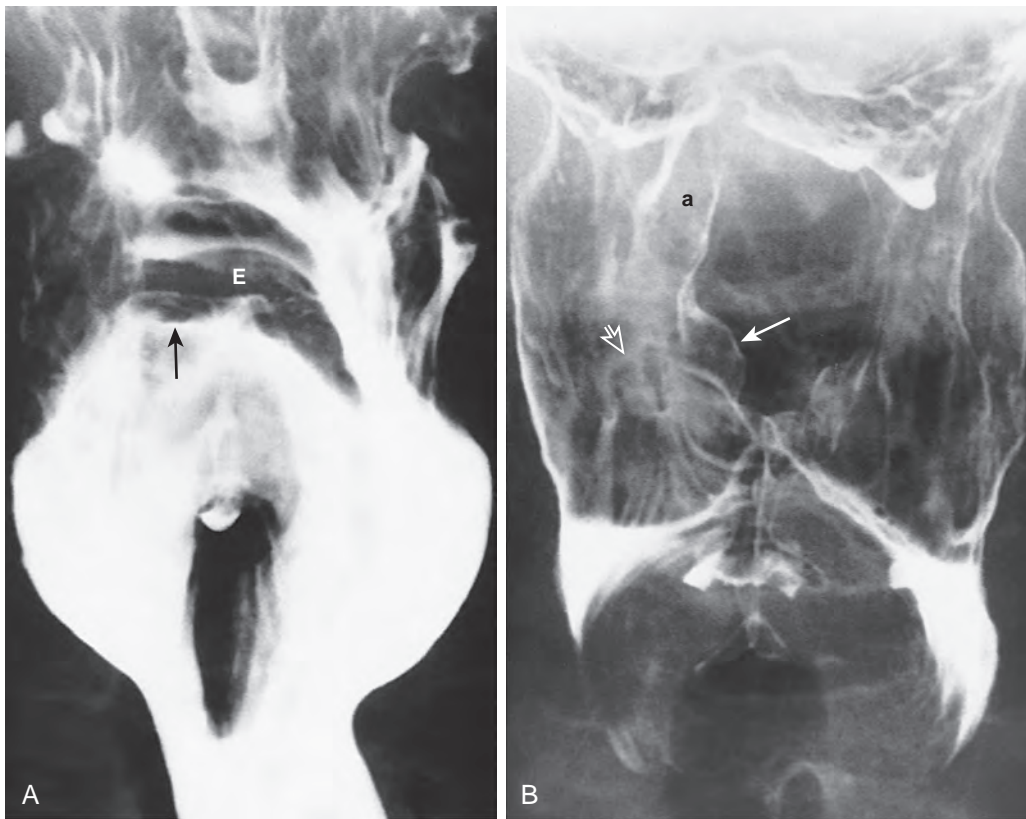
Abnormal epiglottic tilt caused by squamous cell carcinoma involving right aryepiglottic fold and the mucosa overlying the muscular process of the right arytenoid cartilage. A. During swallowing, tilt of the epiglottis (E) is diminished on the right (arrow). B. Frontal spot radiograph shows a small mass (arrow) and thickening of the aryepiglottic fold (a) and nodular mucosa (open arrow). A small squamous cell carcinoma was found to involve the aryepiglottic fold and mucosa overlying the muscular process of the right arytenoid cartilage. (From Rubesin SE: *Pharyngeal dysfunction*. In Gore R [ed]: *Syllabus for Categorical Course on Gastrointestinal Radiology*. Reston, VA, American College of Radiology, 1991, pp 1–9.)
